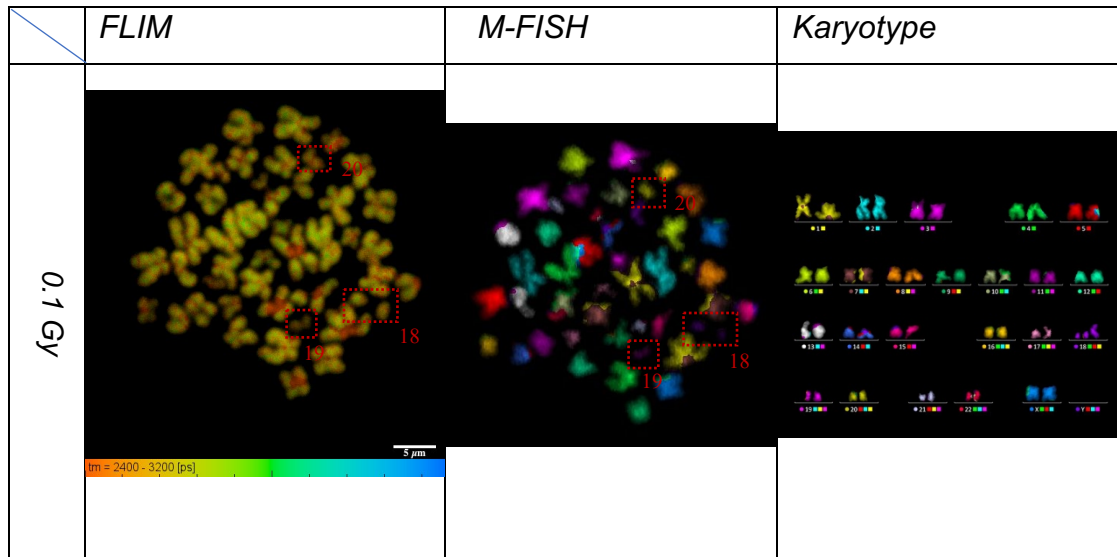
Representation of isochromosome aberrations originated from T-cells exposed to 0.1 Gy X-ray exposure. Red dotted squares shows chromosome underwent isochromosome aberrations. Scale bar= 5 μ m.
